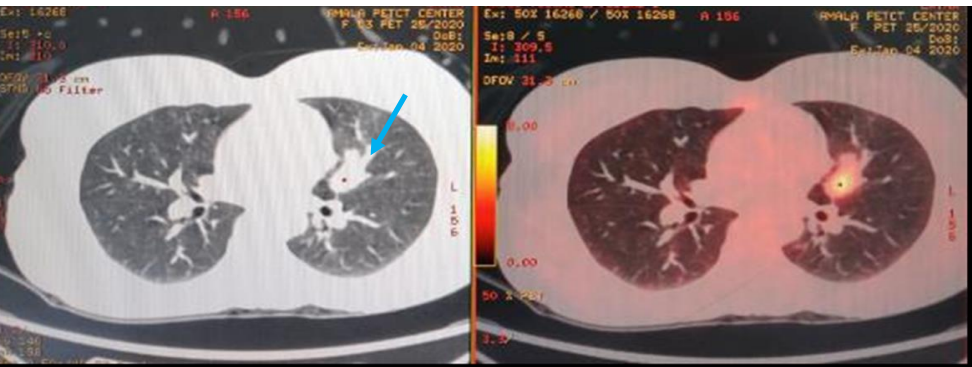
FDG avid left upper lobe lesion (blue arrow)
